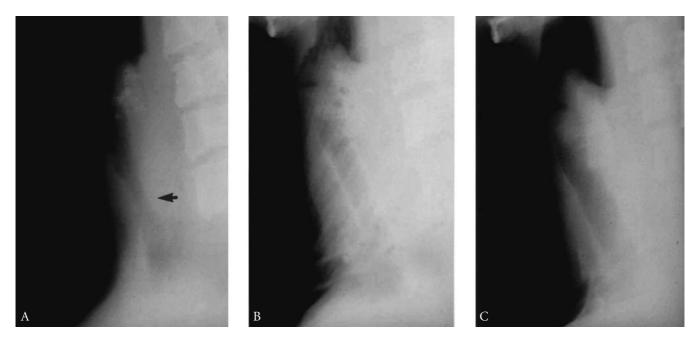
Lateral cervical roentgenograms from an 18-year-old female suffering inhalation burn by toxic gases from combustion of plastic building materials. A, Diffuse upper tracheal stenosis (arrow). Posterior laryngeal calcification is visible superiorly. B, T tube in place, extending from the subglottic larynx into normal trachea. The sidearm of the T lies at the base of the neck. C, Result after 6 years of splinting is an apparently stable although narrowed subglottic larynx and proximal trachea. Dense reactive scar tissue appeared to have resolved to a degree. However, the patient went on slowly to laryngotracheal stenosis, which was successfully treated by laryngotracheal resection and reconstruction 13 years after decannulation (C). She has required several procedures for posterior commissural glottic stenosis and unilateral arytenoid fixation over subsequent years. The laryngotracheal repair has remained stable.
